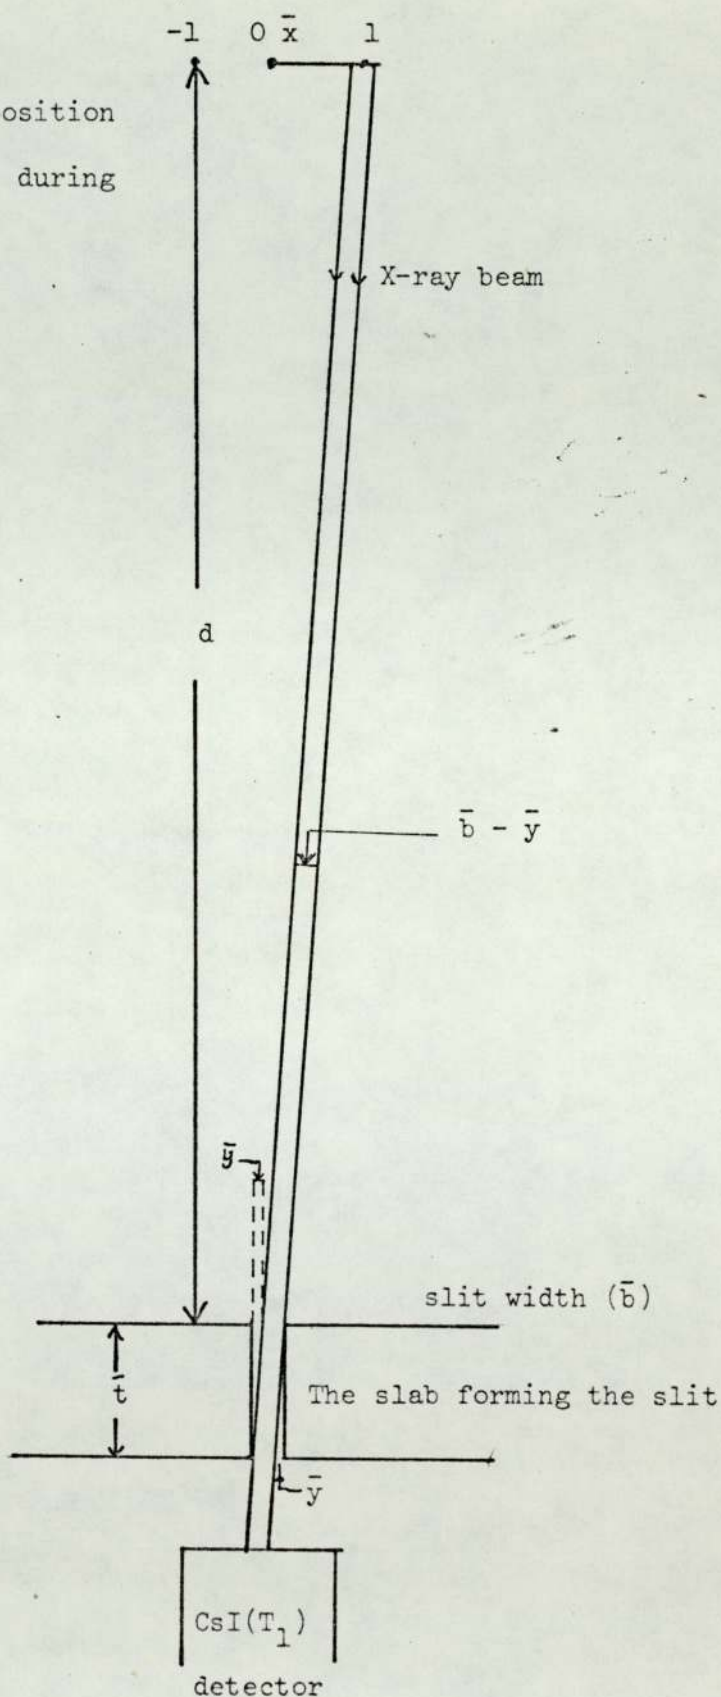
The effect of axial anode movement on the X-rays reaching the detector
